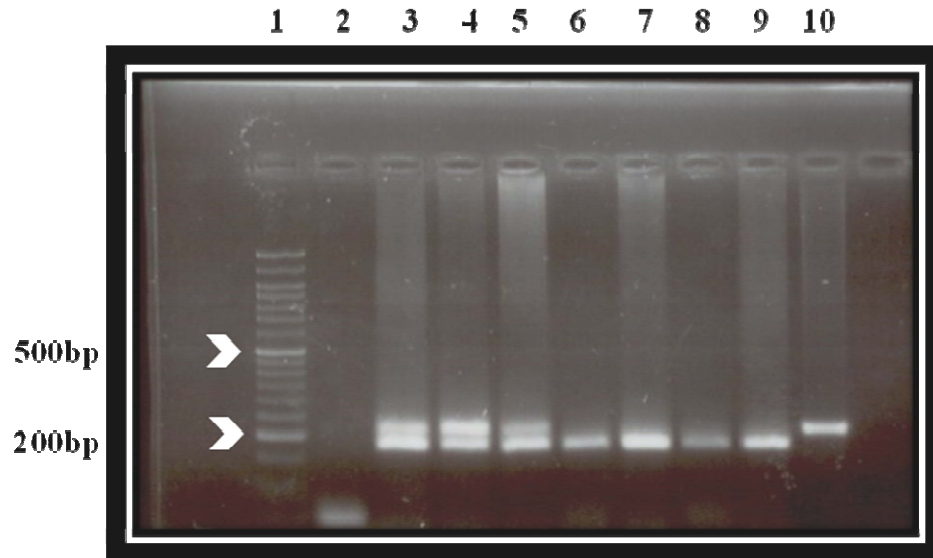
1426 C/T SNP genotyping by RFLP with *HpaII* enzyme. Lane 1 represents the 50 bp DNA ladder; Lane 2 is the negative control, lanes (3-5) show CT genotype with 223/182 bp bands , lanes (6-9) show CC genotype with 182 bp band and lane 10 shows the uncut products with 223 bp band size.
